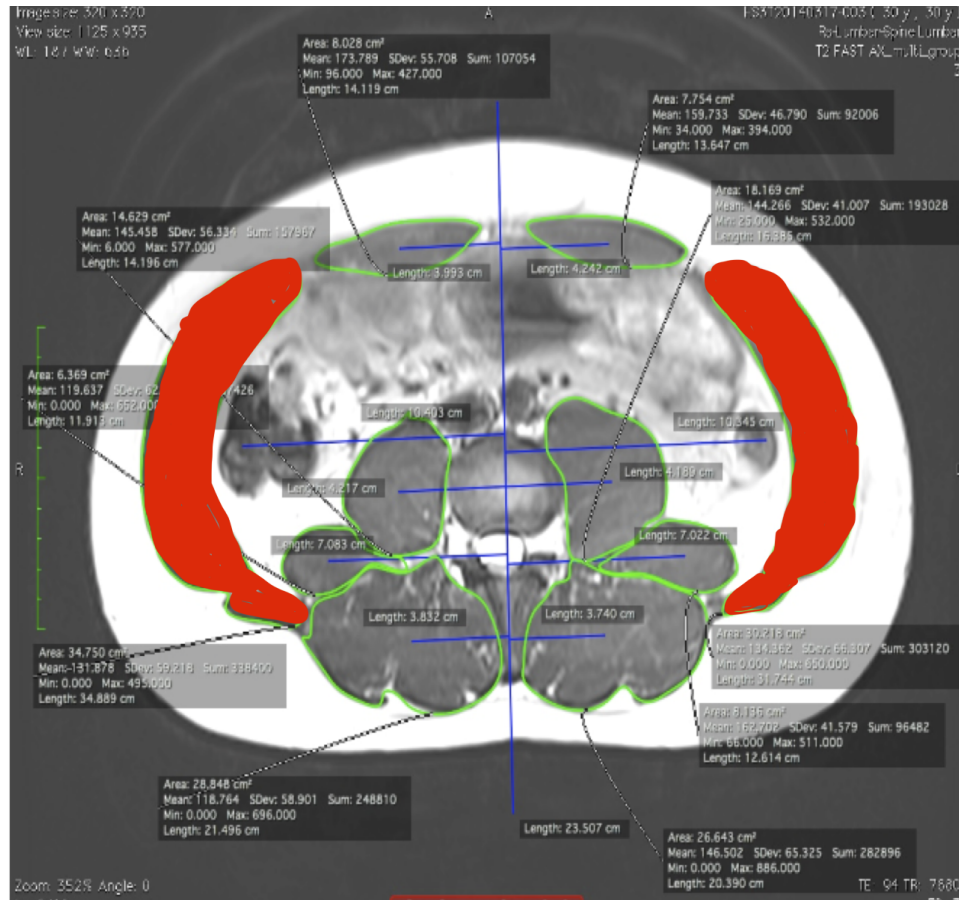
MRI Axial View of the Oblique Muscles
